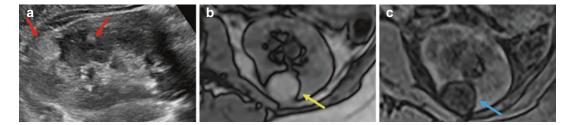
Ultrasound (a) of a patient with tuberous sclerosis with multiple hyperechoic masses (red arrows) compatible with angiomyolipomas (AML) containing fat. On out-of-phase imaging (b), the fat containing AMLs are
